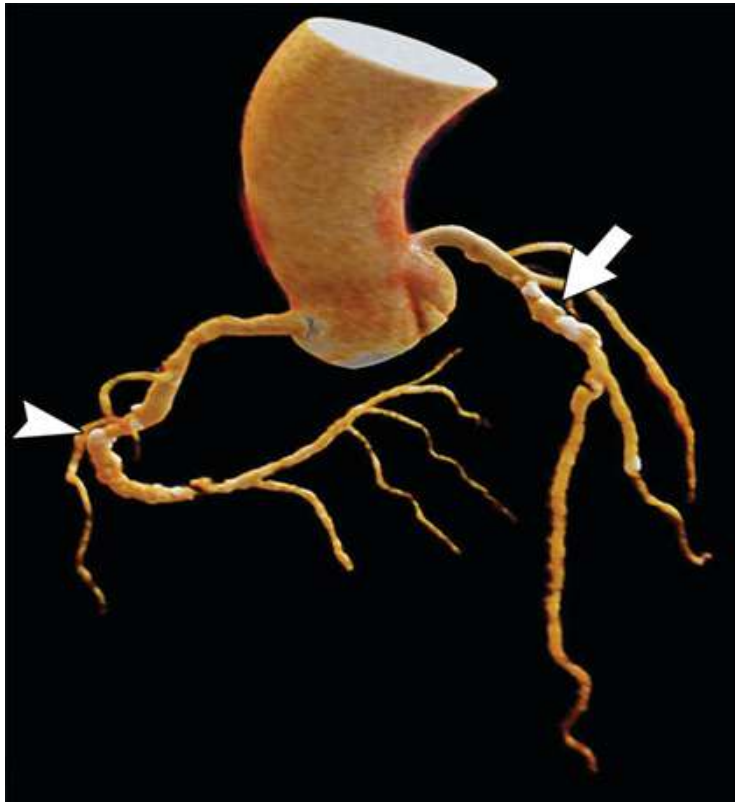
A 70-year-old guy who has chest symptoms is having his heart and coronary arteries CT-angiograph.
